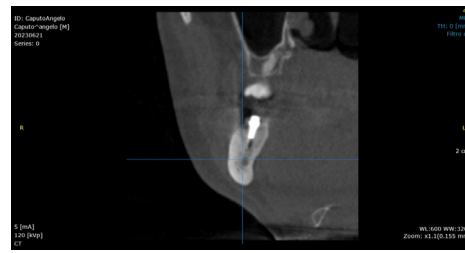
CBCT control at 4 months.
